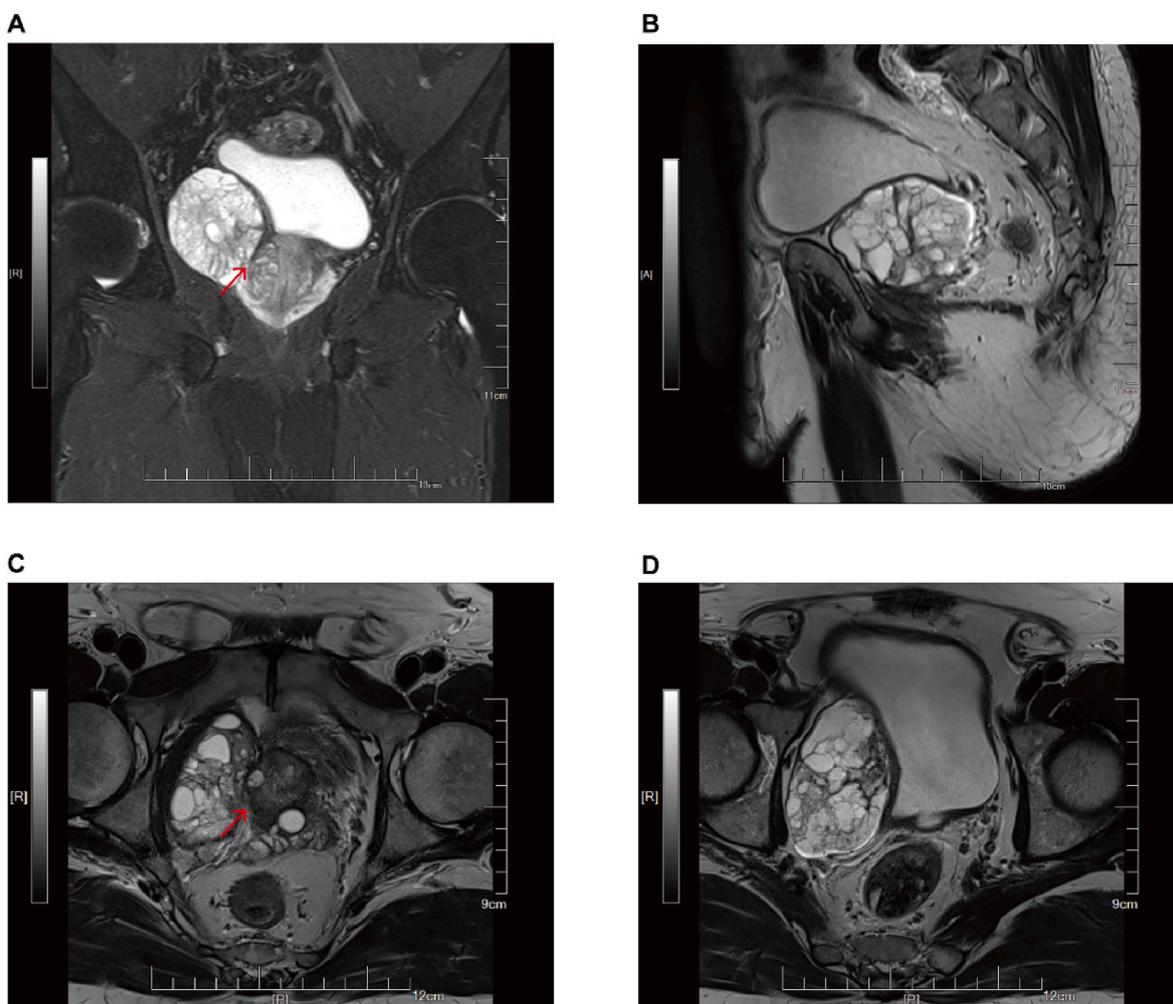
A multi-parametric magnetic resonance imaging of the prostate demonstrated a mixed T2 signal on the right side of the pelvis, measuring approximately 7.6*4.5*4.4 cm. (A, B and C) are coronal, sagittal and horizontal images, respectively. The envelope was intact, the border was clear, and the mass was predominantly multifocal and cystic. It was in continuity with the prostate (arrow) and the bladder was compressed. The prostate was enlarged, measuring about 5*3.7*4.4 cm.
